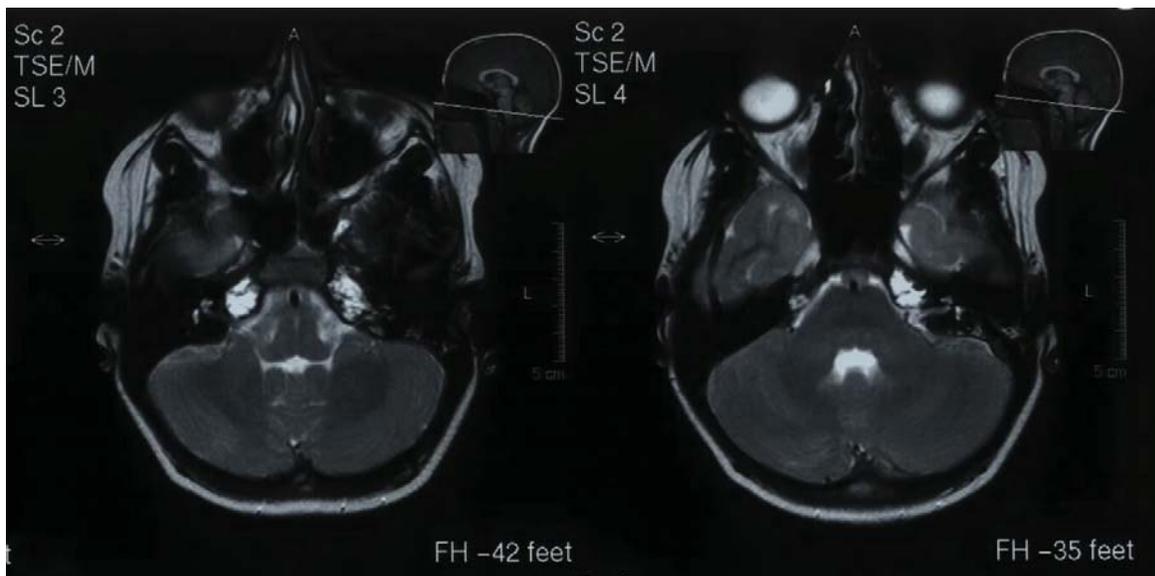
Axial view of the magnetic resonance image of the brain stem showing the extensiveness of thrombosis in the bright areas
